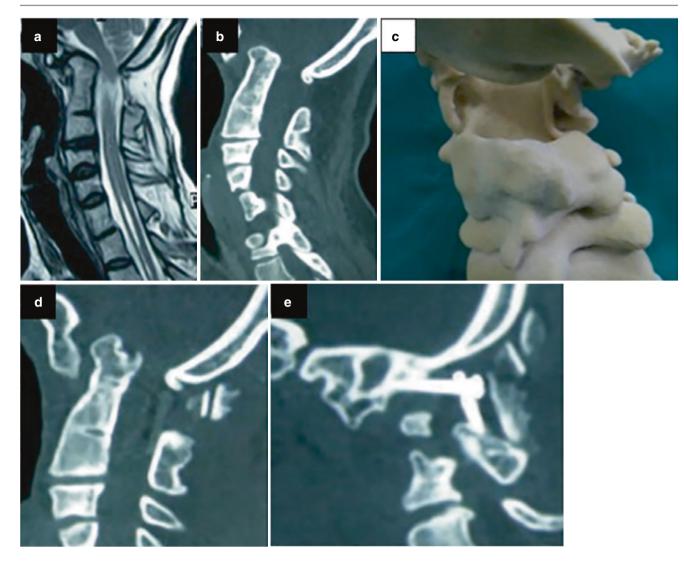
Imaging findings in a 36-year-old woman. Preoperative T2-weighted magnetic resonance imaging shows basilar invagination, a Chiari malformation, and syringomyelia (a). Computed tomography (CT) demonstrates fusion of the C2–C3 vertebrae, assimilation of the atlas, basilar invagination, and atlantoaxial dislocation (b). A three-dimensional model defines assimilation of the atlas and C2–C3 fusion
